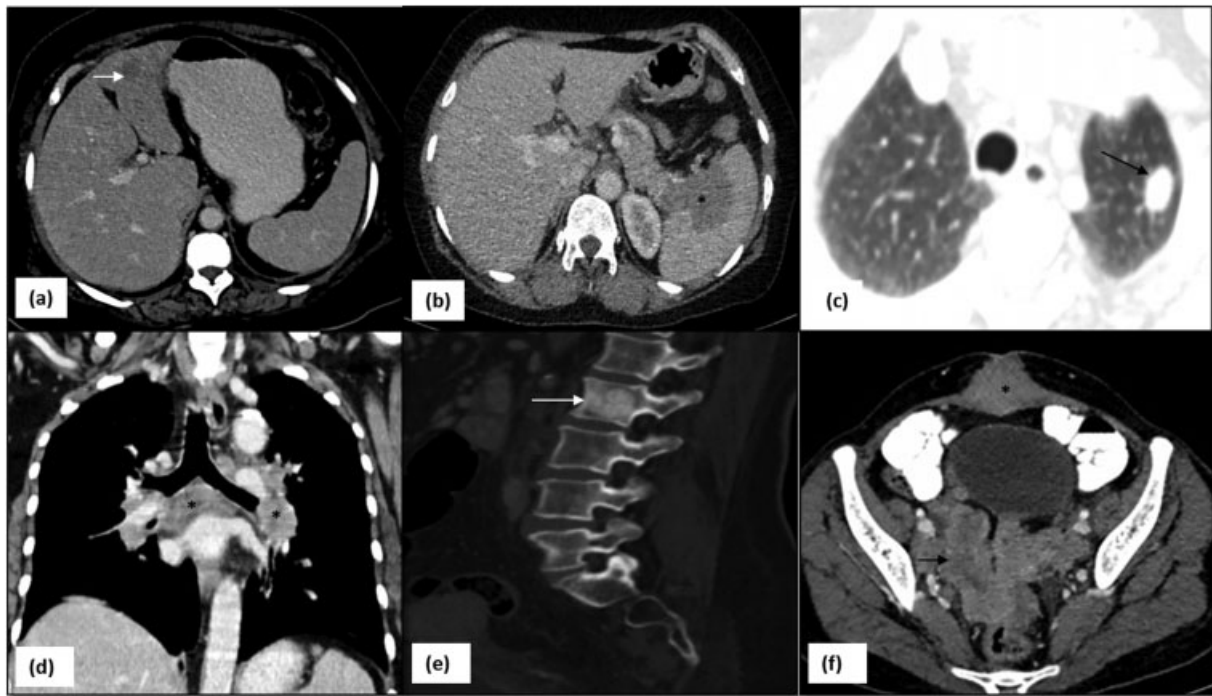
CT images showing various sites of metastatic disease in carcinoma cervix: (a) liver (arrow), (b) spleen (asterisk), (c) lung (arrow), (d) mediastinal lymph nodes (asterisk), (e) sclerotic metastasis in vertebrae (arrow), (f) abdominal wall (asterisk), serosal deposits (arrow).
